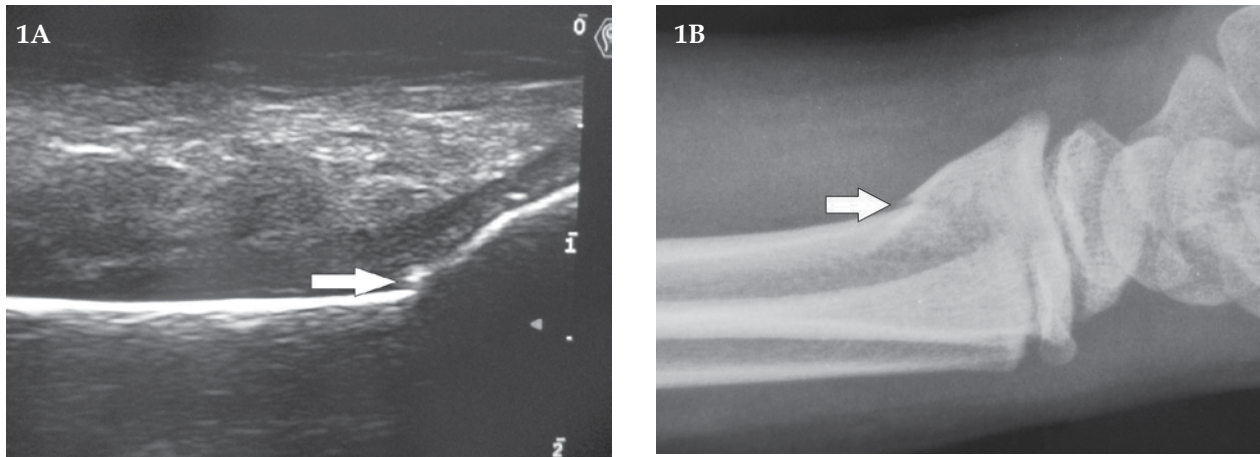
The arrow in both figures (ultrasound 1a and x-rays 1b), shows a green stick fracture
